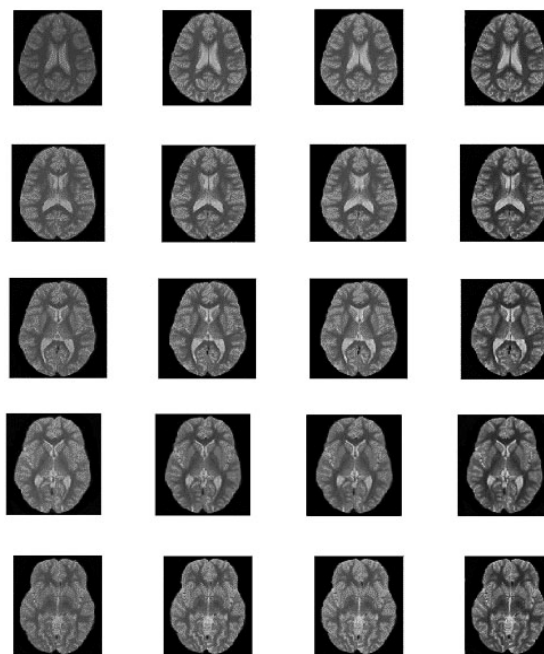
T2-weighted original images (first column) and the images enhanced using WNM-1, WNM-2 and the polynomial based method.
